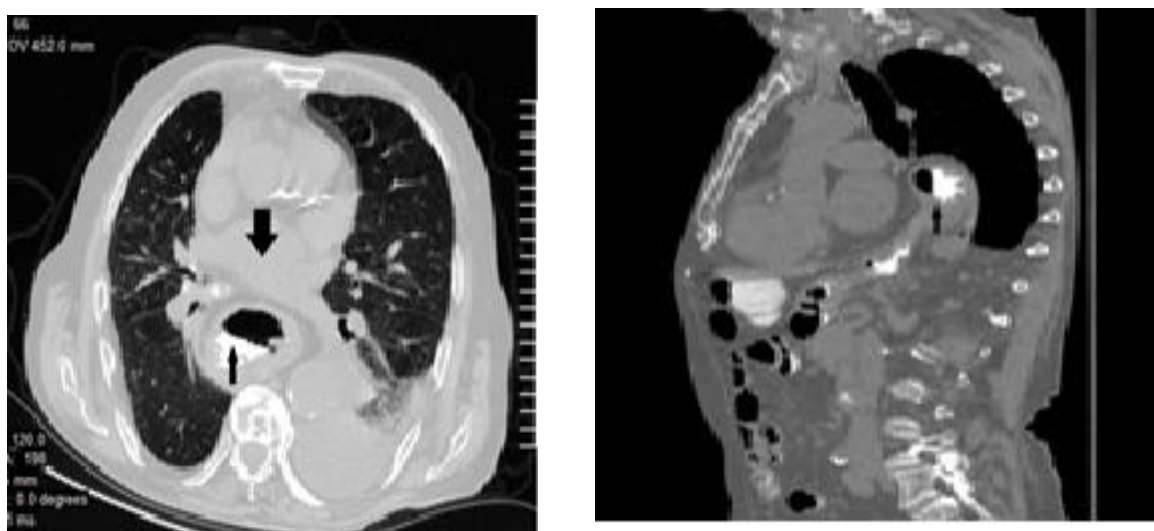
Emergent chest / abdominal CT scan (axial /sagittal views) of a 88-year old man, depicting PEH (thin arrow) and cardiovascular deviation (thick arrow : pulmonary trunk). He underwent emergent gastrectomy.
